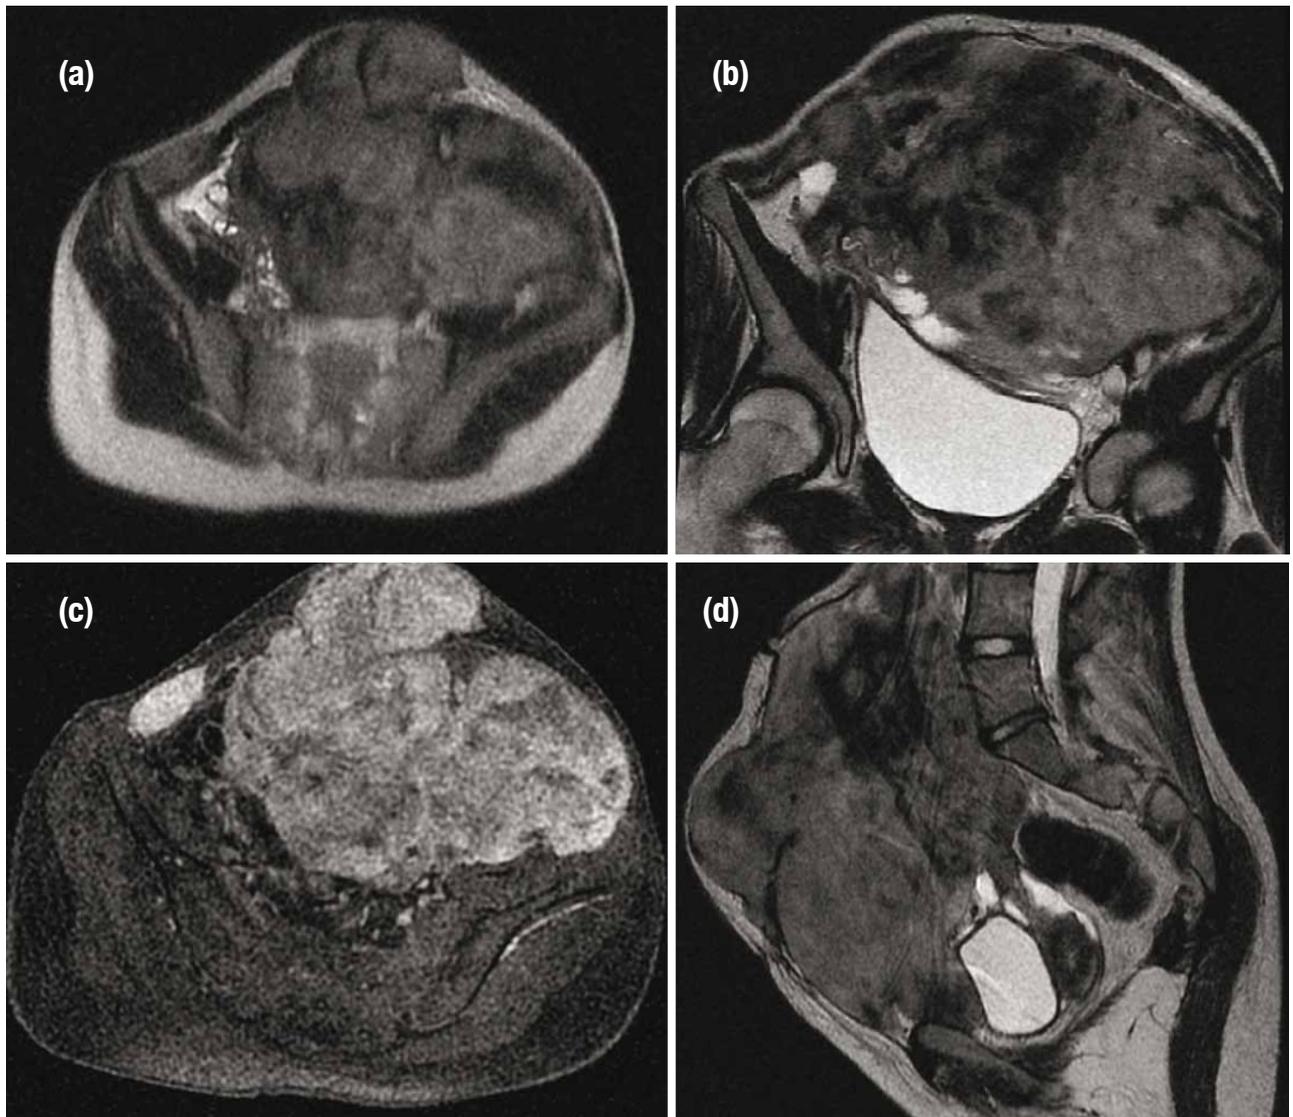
MRI unenhanced T1 (a) and T2 (b, d) weighted images and contrast-enhanced T1-weighted image (c) showing intra-abdominal (circle) and paravertebral tumors (star).
